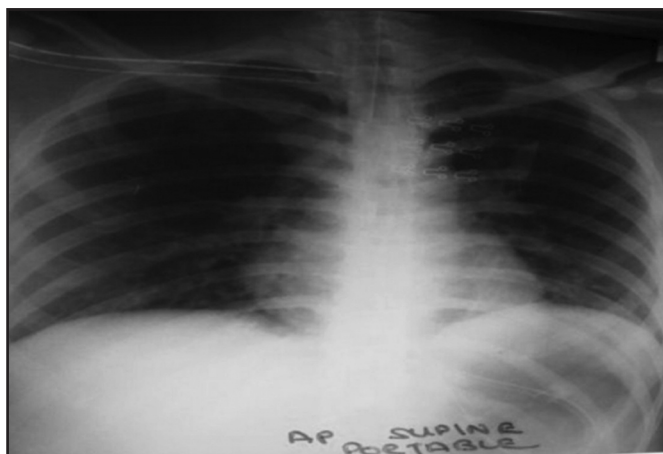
Chest X-ray film at arrival to our facility which shows normal lung fields at 1327 H.
